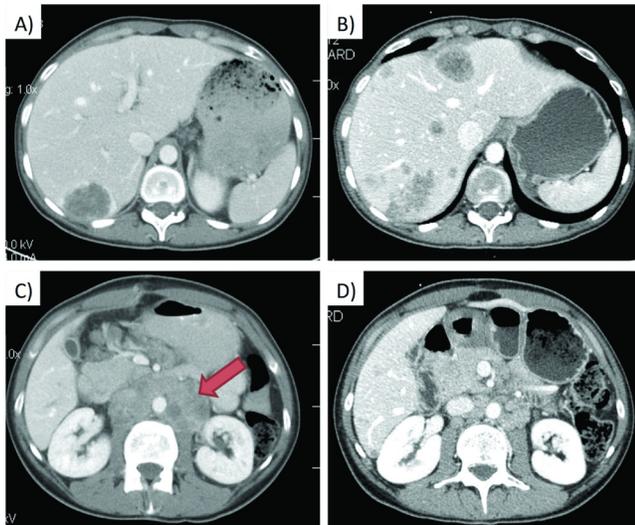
(A,B) Computed tomography images of the hepatic metastases in patient 2 that progressed during treatment with bevacizumab. (C,D) A para-aortic lymph node metastasis that decreased in size during the same period. Sequencing demonstrated amplification of vascular endothelial growth factor A in the liver lesions, but not in the primary tumour, which had been sampled before bevacizumab treatment.
